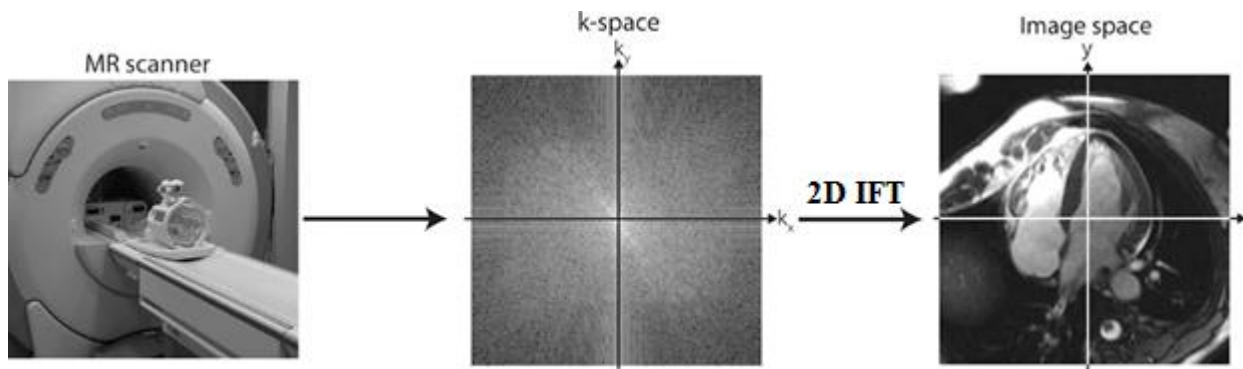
The flow of acquiring an MRI image [50].
